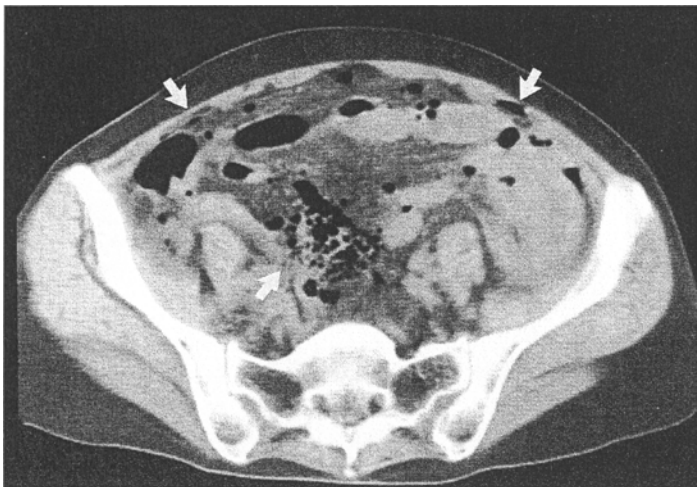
63-year-old woman with spontaneous rectal perforation. CT image shows the finding of dirty mass in the center of the small pelvic cavity (arrow). Multiple areas of intraperitoneal free air can also be noted just behind the abdominal wall (arrows).
